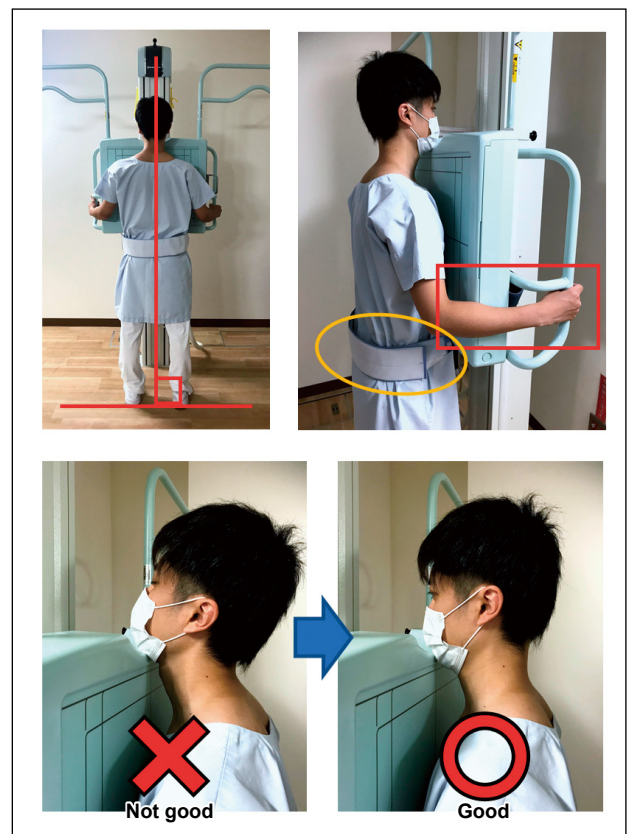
Positioning Measures for Standing Radiography
